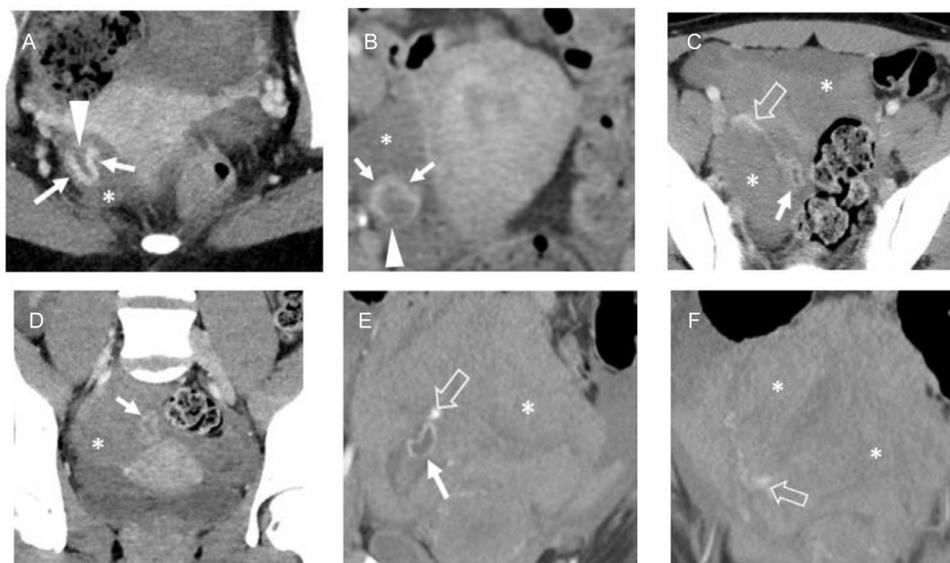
Women with Mittelschmerz syndrome present midmenstrual cycles with acute pelvic pain and imaging findings of rupture corpus luteal cyst and free fluid (asterisk). (A) and (B) axial CT images show the classic wavy (arrows) discontinuous enhancement (arrowhead) of a ruptured corpus luteal cyst with adjacent free fluid in reproductive age women presenting with midmenstrual cycle pelvic pain. (C) and (D) axial and coronal CT images shows a ruptured corpus luteal cyst (arrow), hemoperitoneum (asterisk), and active extravasation (open arrow) in a patient who required emergent oophorectomy due to hemorrhagic shock. (E) and (F) axial and coronal CT images show a different patient requiring emergent oophorectomy for hemorrhagic shock due to a ruptured corpus luteal cyst (arrow) with active extravasation (open arrow) and hemoperitoneum (asterisk).
